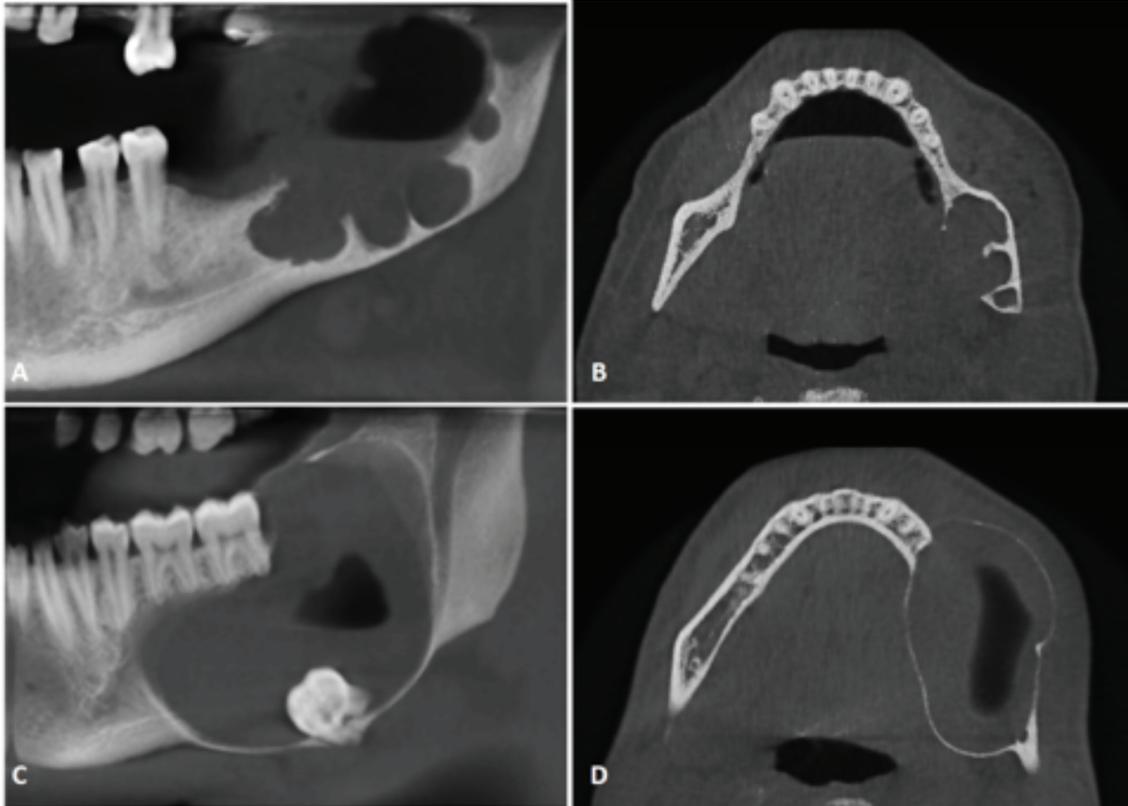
CBCT: A- Case 1, multiloculated hypodense image; B- Case 1, expansion of lingual cortical bone; C- Case 2, hypodense unilocular image with apical displacement of the lower left third molar; D- Case 2, important cortical bone expansion.
